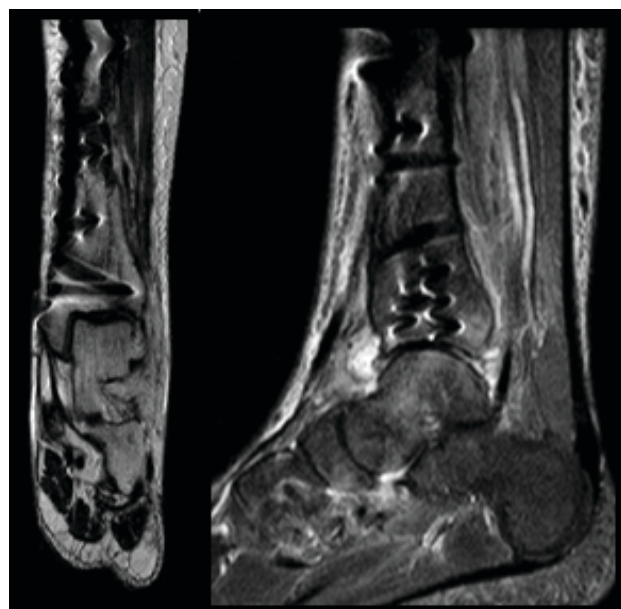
Post-operative X-rays (a,b) and follow up MRI (c,d)
